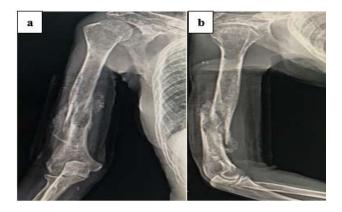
(a) Antero-posterior and (b) lateral view of right shoulder x-ray.
